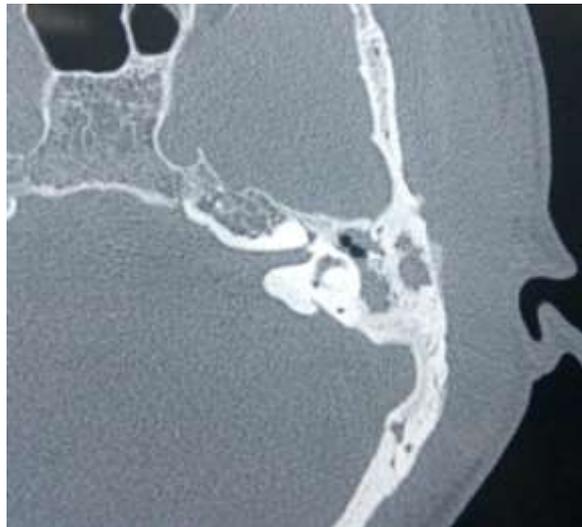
HRCT temporal bone showing soft tissue density in left mastoid and middle ear with left zygomatic collection
